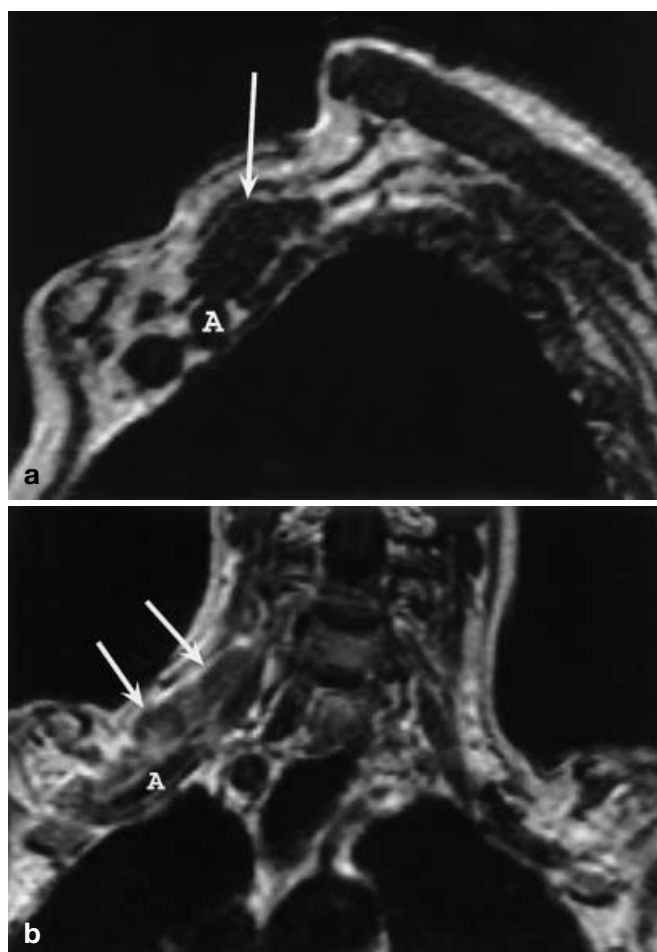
A patient with neurolymphomatosis of the brachial plexus (B-cell non-Hodgkin's lymphoma). a Sagittal T1-weighted image at the level of the divisions demonstrates a thickened brachial plexus (*arrow*). *A* subclavian artery. b Coronal contrast-enhanced T1-weighted image shows a slightly enhancing diffusely thickened brachial plexus (*arrows*)
